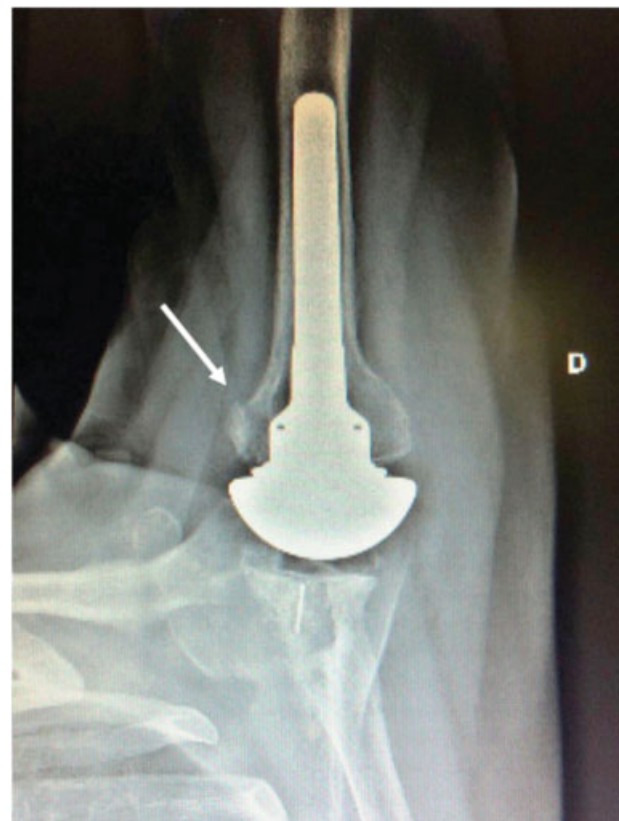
Axillary lateral radiography showing lesser tuberosity healing after total shoulder arthroplasty.
